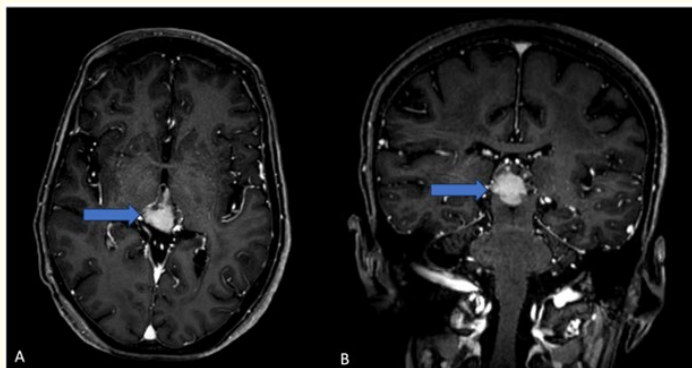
Pineoblastoma in 16 years old. Axial (A) and coronal (B) T1-weighted gadolinium-enhanced image showed homogeneous and intense enhancement of the tumor (arrows). It is important to note that there is no associated leptomeningeal enhancement.
